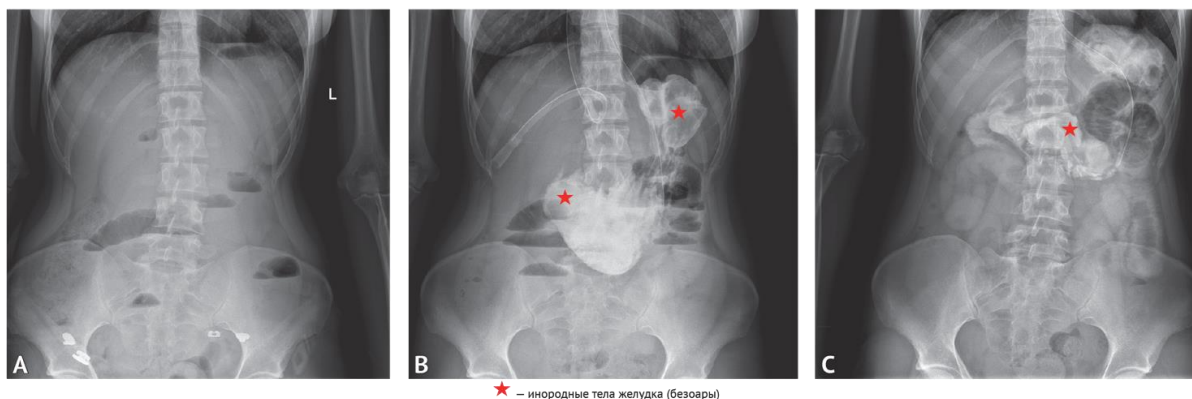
Plan X-ray image of the abdominal organs (A); B — the beginning of the study of the passage of a water-soluble X-ray contrast agent along the gastrointestinal tract; C — 4 hours after the beginning of the study
